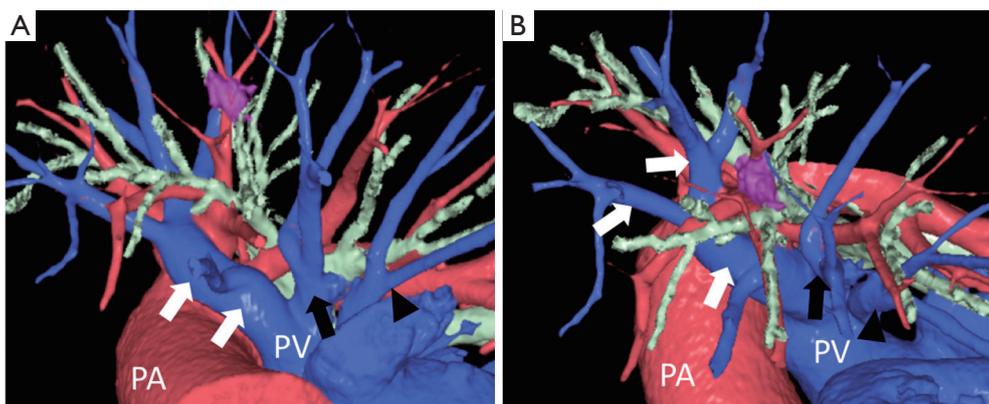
The tumor and bronchovascular tree using 3D reconstruction of multi-detector CT data. (A) 3D-CT image. Images of arteries (red), veins (blue), bronchi (green), and tumor (magenta) are reconstructed by surgeons; (B) rotated 3D-CT image. The tumor is located between subsegmental bronchi, B3a, B3b and B3c. Black arrow, V3 (vein between S3 and S4); white arrow, V1+2 (vein between S1+2 and S3); black arrowhead, V4+5 (lingular vein). PA, pulmonary artery; PV, pulmonary vein; 3D-CT, three-dimensional computed tomography.
